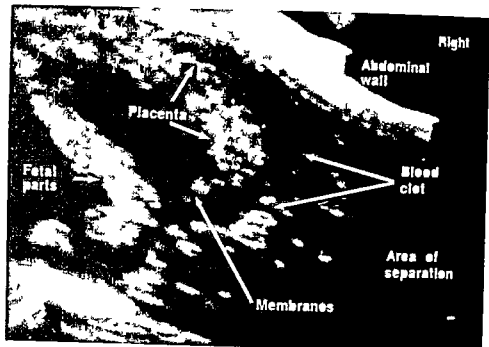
17 Sonogram showing partial placental abruption at lateral edge of placenta with revealed bleeding
